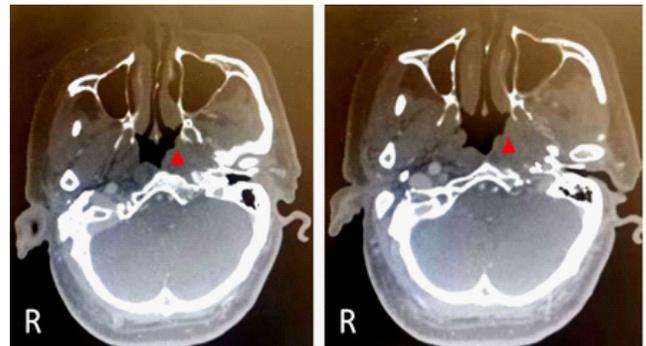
Representative coronal sections of a pre-antifungal treatment CT nasopharynx with contrast demonstrating the pharyngeal recess disappeared and bulged out (red triangle Δ).
